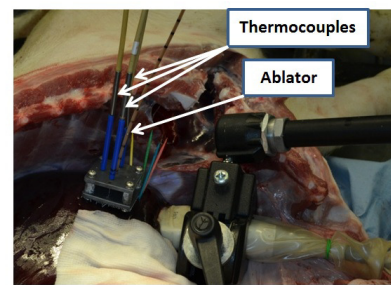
(a) In situ liver ablation and data acquisition setup. Four prongs enter the tissue: the ablator in the middle, and thermocouples at distances of 1.5, 1, and 1 cm. (b and c) Ablated slices of the tissue corresponding to the ultrasound imaging planes. The planes of ultrasound images are shown as blue rectangles.
